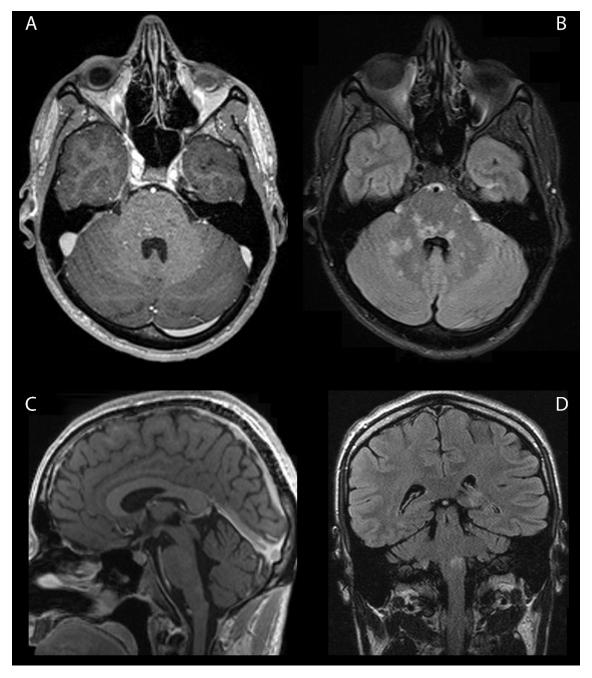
Case 2. A. Transversal brain FLAIR MRI showes small patchy hyperintensities of the pons and mesencephalon, to a lesser extent in both thalami, cerebellar peduncles and cerebellar hemispheres. B. Transversal T1 brain stem Gd+ hyperintensities. C. Sagital T1 MPR brain stem with residual nonenhancing lesions after ocrelizumab treatment. D. Coronal T1 with a residual lesion in medulla oblongata after ocrelizumab treatment.
